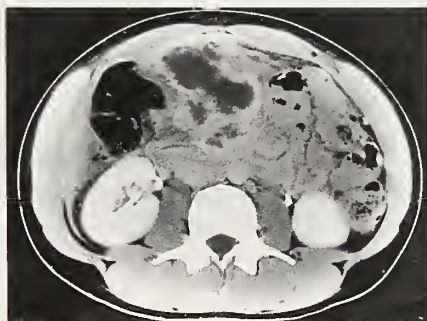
Admission CT scan of the abdomen showing a large pancreatic phlegmon.
